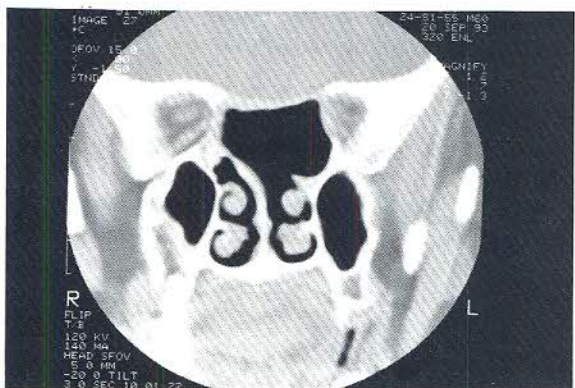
Case 1. CT scan (with IV contrast) taken 4 months after surgery shows an empty mucocele cavity in the ethmoid and sphenoid sinuses.
